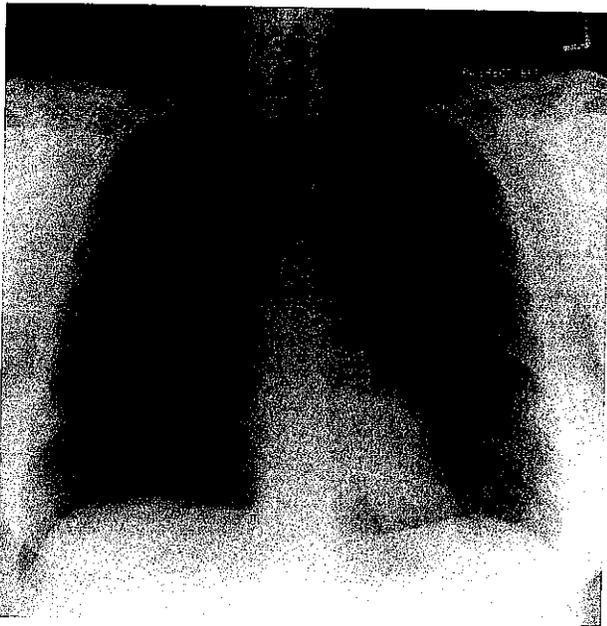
Chest X-ray demonstrating an aspergilloma of the right middle lobe.
